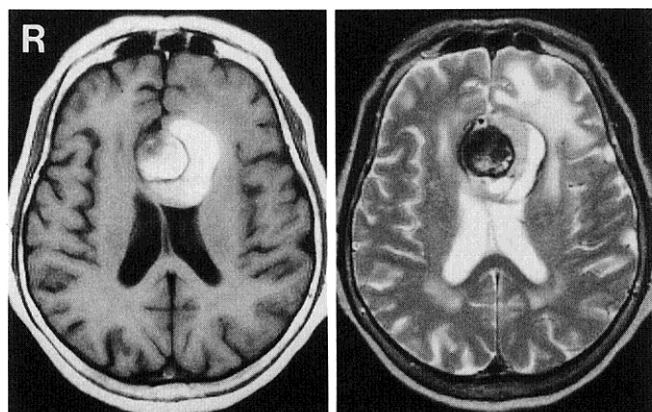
Magnetic resonance images showing a large globoid lesion consisting of two parts. The lower part was hyperintense on both T_1 - (left) and T_2 -weighted (right) images, which suggested a hematoma containing free methemoglobin, whereas the upper part was inhomogeneously hyperintense on T_1 - and inhomogeneously hypointense on T_2 -weighted images, which suggested old thrombus containing hemosiderin and flow void signal.
